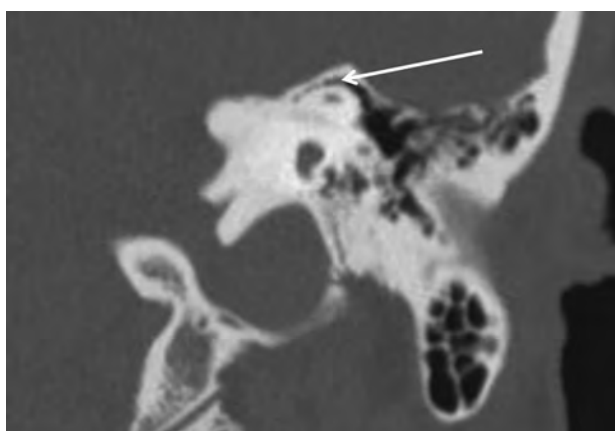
Air cells overlying the superior semicircular canal. Coronally reformatted CT of the temporal bone demonstrates an intact superior semicircular canal (arrow) with overlying air cells. When air cells are present, the canal should be classified as nondehiscent, regardless of the thickness of bone covering the canal or underlying the dura.
